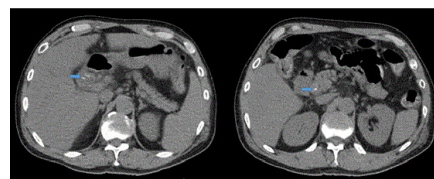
Abdominal computed tomography demonstrating (A) hyperdense material corresponding to surgical clip in the end of remnant cystic duct and (B) hyperdense material in the common bile duct.
